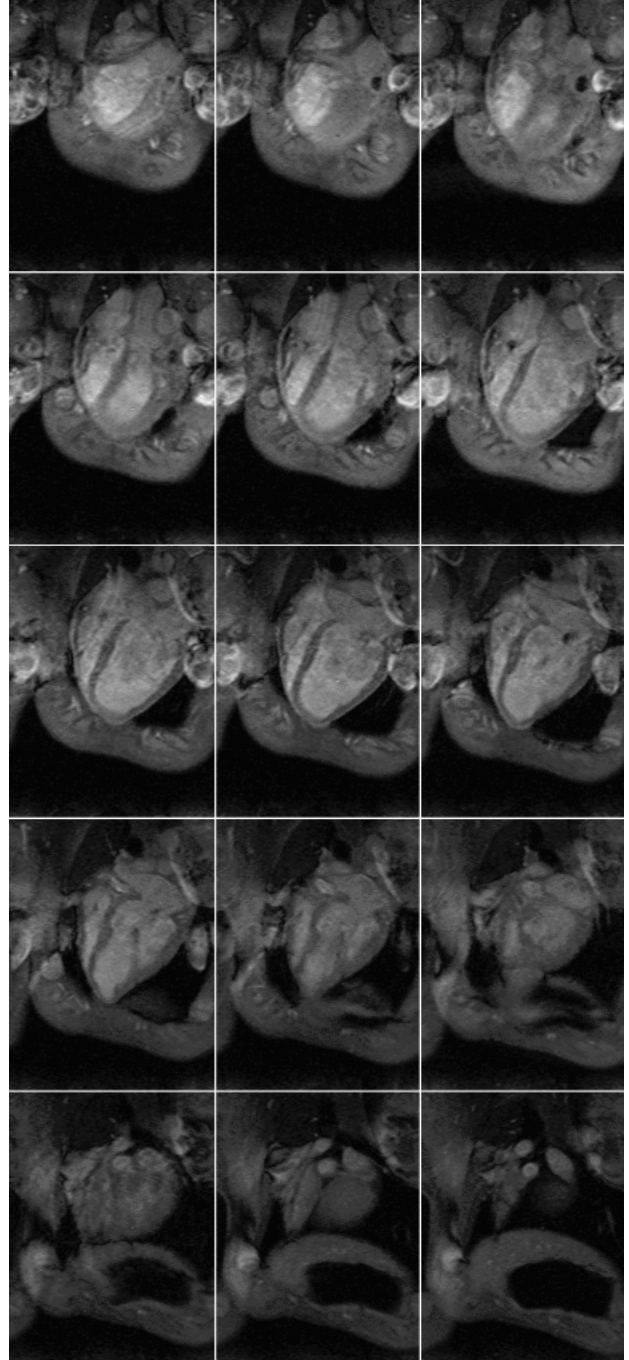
Volumetric MRI data used in the experiments.
